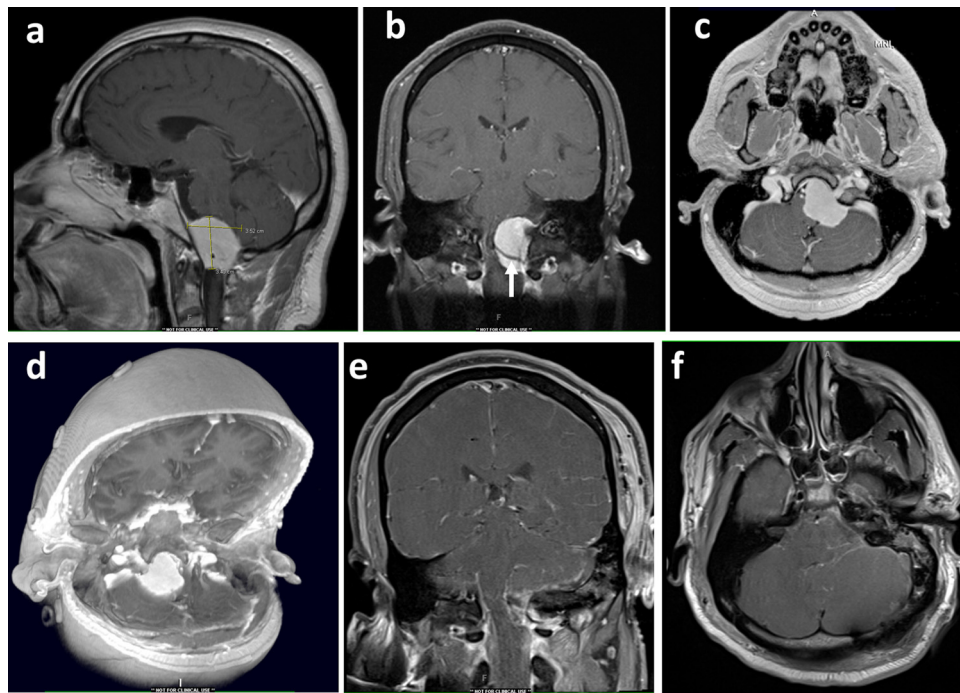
This 45-year-old male patient experienced neck pain, headache, vertigo and numbness in his left thigh. MRI scans (a–c) and CT reconstruction (d) revealed a very large craniospinal meningioma ($3.4 \text{ cm} \times 3.5 \text{ cm} \times 2.5 \text{ cm}$) displacing significantly the brain stem laterally and wrapped around the vertebral artery (arrow). He underwent left suboccipital craniectomy with a far-lateral approach through a transcondylar route to the posterior fossa. Post-operatively, he recovered reasonably well after a transient dysphagia after surgery. He developed some difficulty in temperature sensation on the left side of the trunk. MRI (e and f) at follow-up showed evidence of small amount of enhancement at the level of the insertion of the tumor, but no significant compression of the brain stem.
